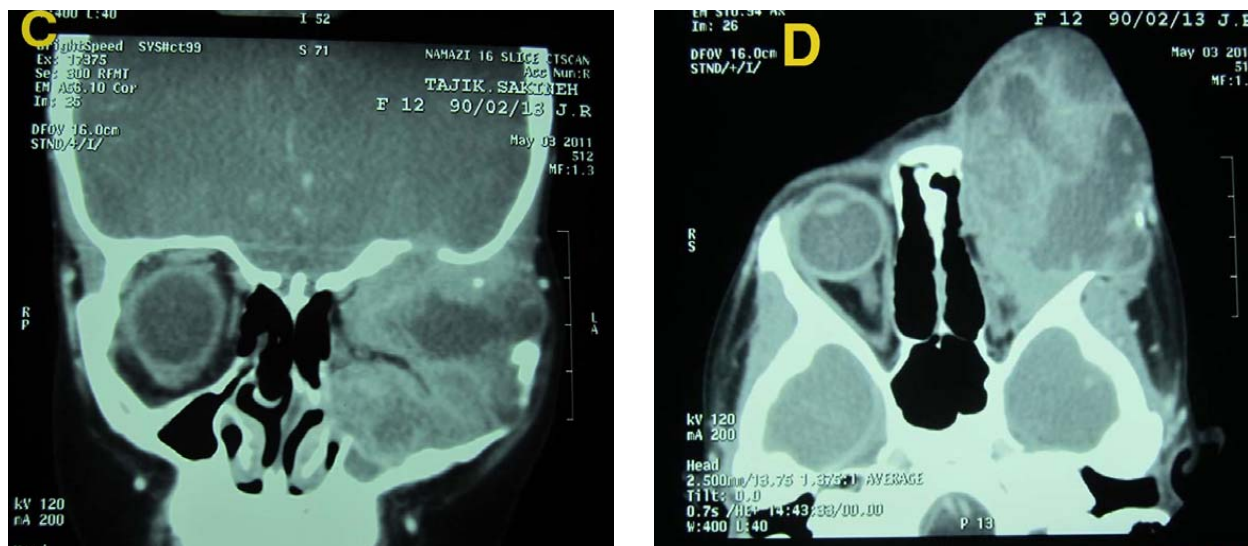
(C, D): CT scan of orbit showed a huge orbital mass in the left orbit extended to the posterior portion with optic nerve destruction, frontal, ethmoid and maxillary sinuses were also involved. A soft tissue mass is observed outside of the orbit protruding to the zygomatic bone and ear canal.
